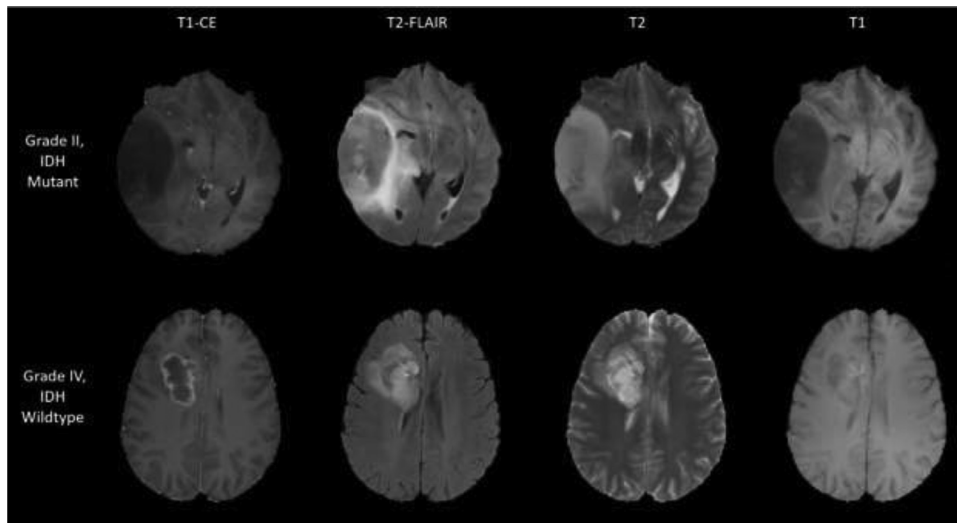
Sample MRI acquisition in neuro-oncology. Figure shows eight axial slices of two patients from the TCIA dataset. In the top row, brain MRI images from a 28-year-old male with Oligoastrocytoma (Grade II, IDH Mutant), whereas in the bottom row, images from a 33-year-old female with Glioblastoma (Grade-IV, IDH-Wildtype) are shown. From left to right: two slices are of each modality namely T1 contrast enhanced (T1-CE), T2-weighted with Fluid Attenuated Inversion Recovery (T2-FLAIR), T2-weighted, T1-weighted are shown.
